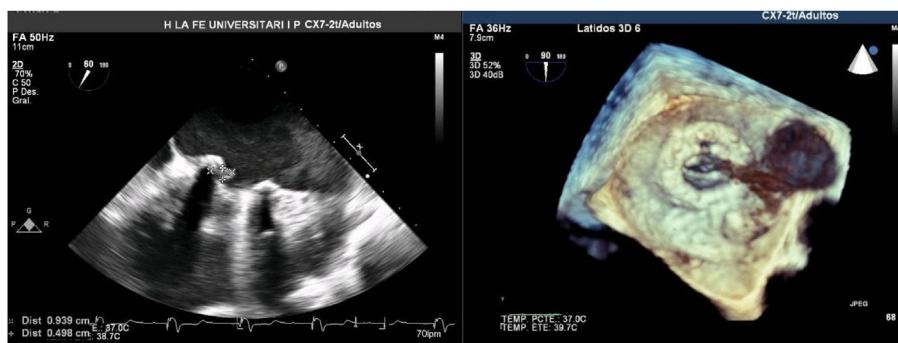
Transesophageal echocardiography, shows vegetation on the medial side of the prosthetic ring of about 8 mm.
